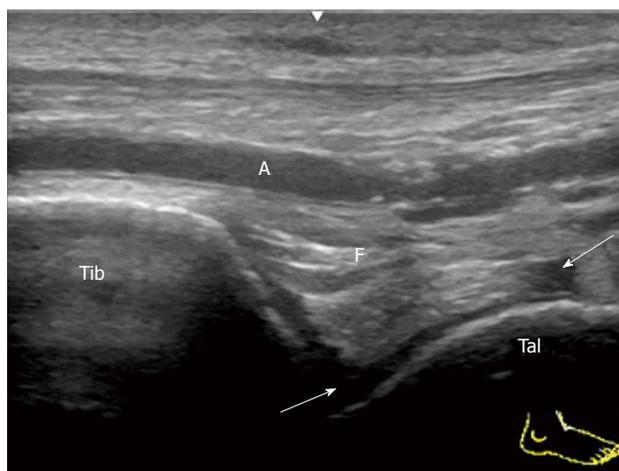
Mild tibiotalar joint synovitis in reactive arthritis. Sagittal grey-scale sonogram of the anterior recess of the tibiotalar joint shows localized anechoic synovial effusion (arrow). Tib: Tibia; Tal: Talus; F: Fat pad; A: Dorsalis pedis artery.
